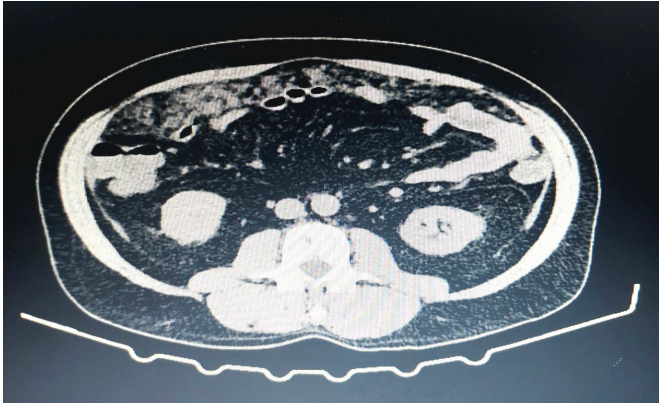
Diffuse omental thickening in CT abdominal.
